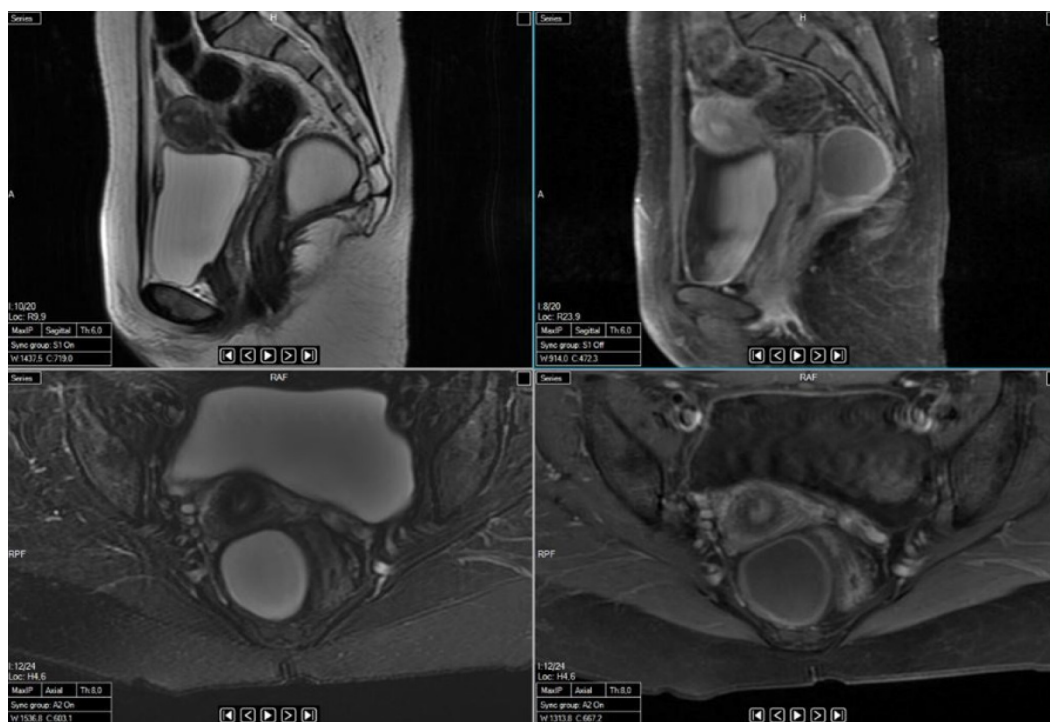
Sagittal and axial magnetic resonance images showing a cystic teratoma localized in the retrorectal area.
